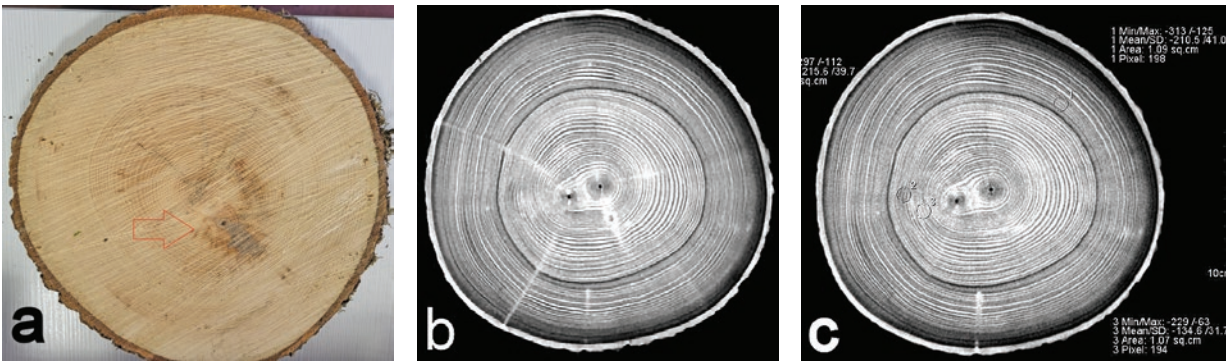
Sample Radinje 5, a) photograph, b) CT scan, c) CT scan with ROI values
